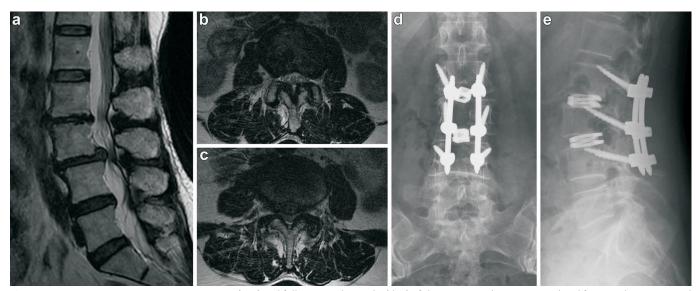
Preoperative magnetic resonance images (a–c) and follow-up radiographs (d, e) of the patient with L2–L4 central and foraminal stenoses, and spondylolisthesis who presented with claudication, and incontinence.
